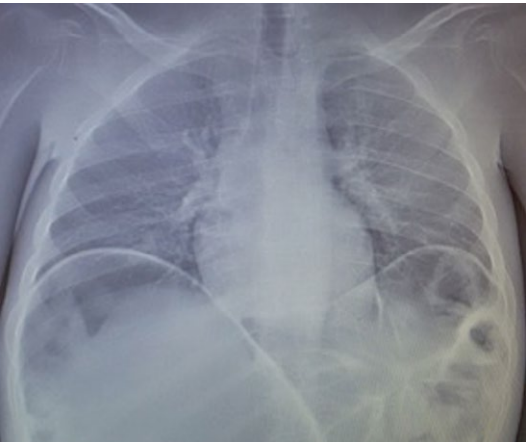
A chest X-ray showing dilated bowel loops and upward displacement of the diaphragm.
